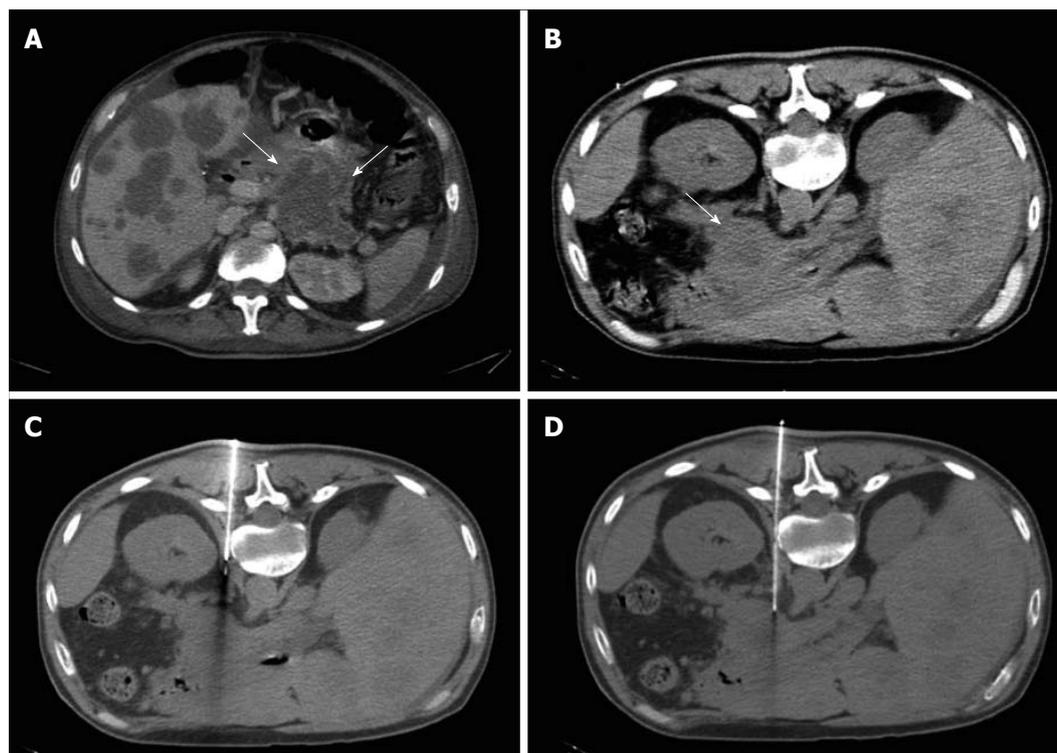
Percutaneous computed tomography -guided core needle biopsy of a pancreatic lesion using hydrodissection. A: Contrast-enhanced computed tomography (CT) showing an expansive lesion in the tail of the pancreas (arrows). An anterior approach was considered difficult because of the interposition of the intestine in the supine position, therefore, a posterior approach was used; B: Non-enhanced axial CT of the upper abdomen in the prone position showing a lesion located in the tail of the pancreas (arrow); C: Coaxial needle (17 G) positioned in the pillar of the diaphragm, where saline solution was injected to enlarge the paravertebral space, enabling an unobstructed needle path; D: Biopsy needle (18 G) placed adjacent to the pancreatic lesion.
